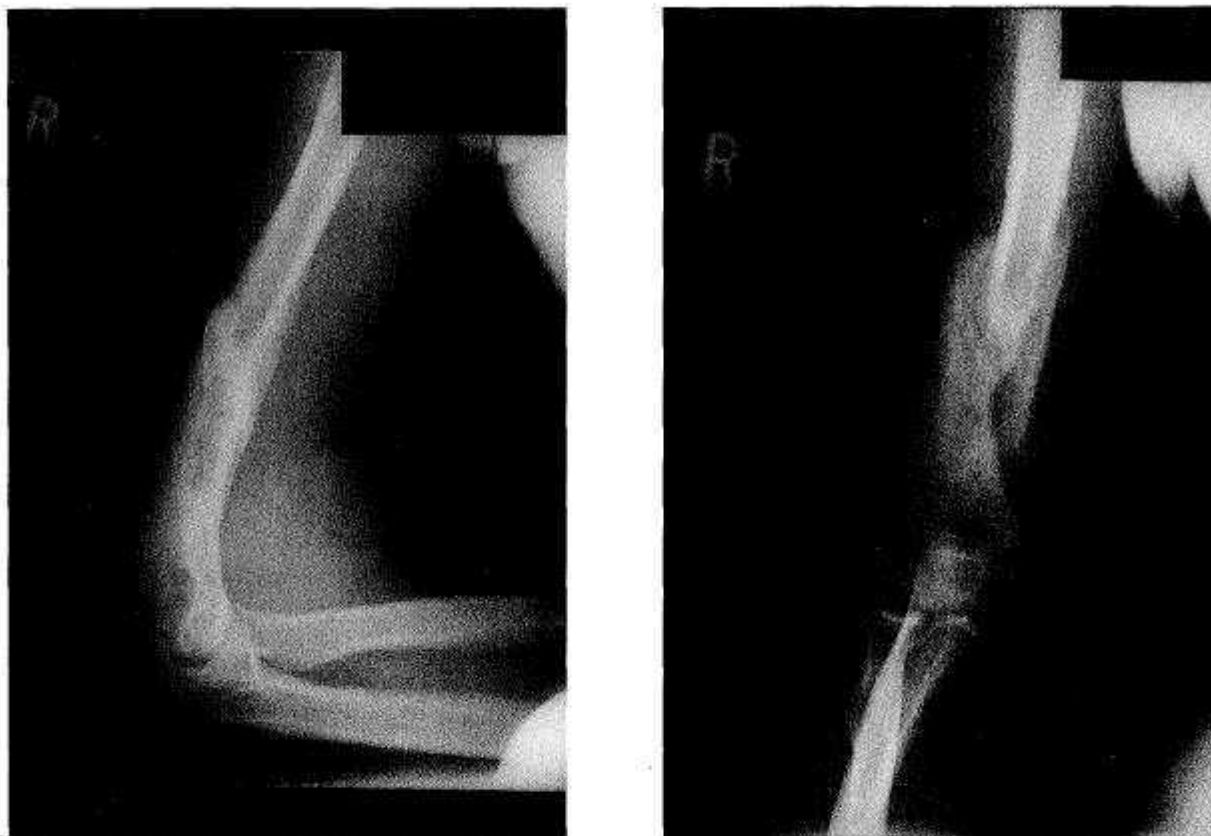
Radiographs of the humerus following conservative treatment. The fracture is healed with acceptable alignment.
